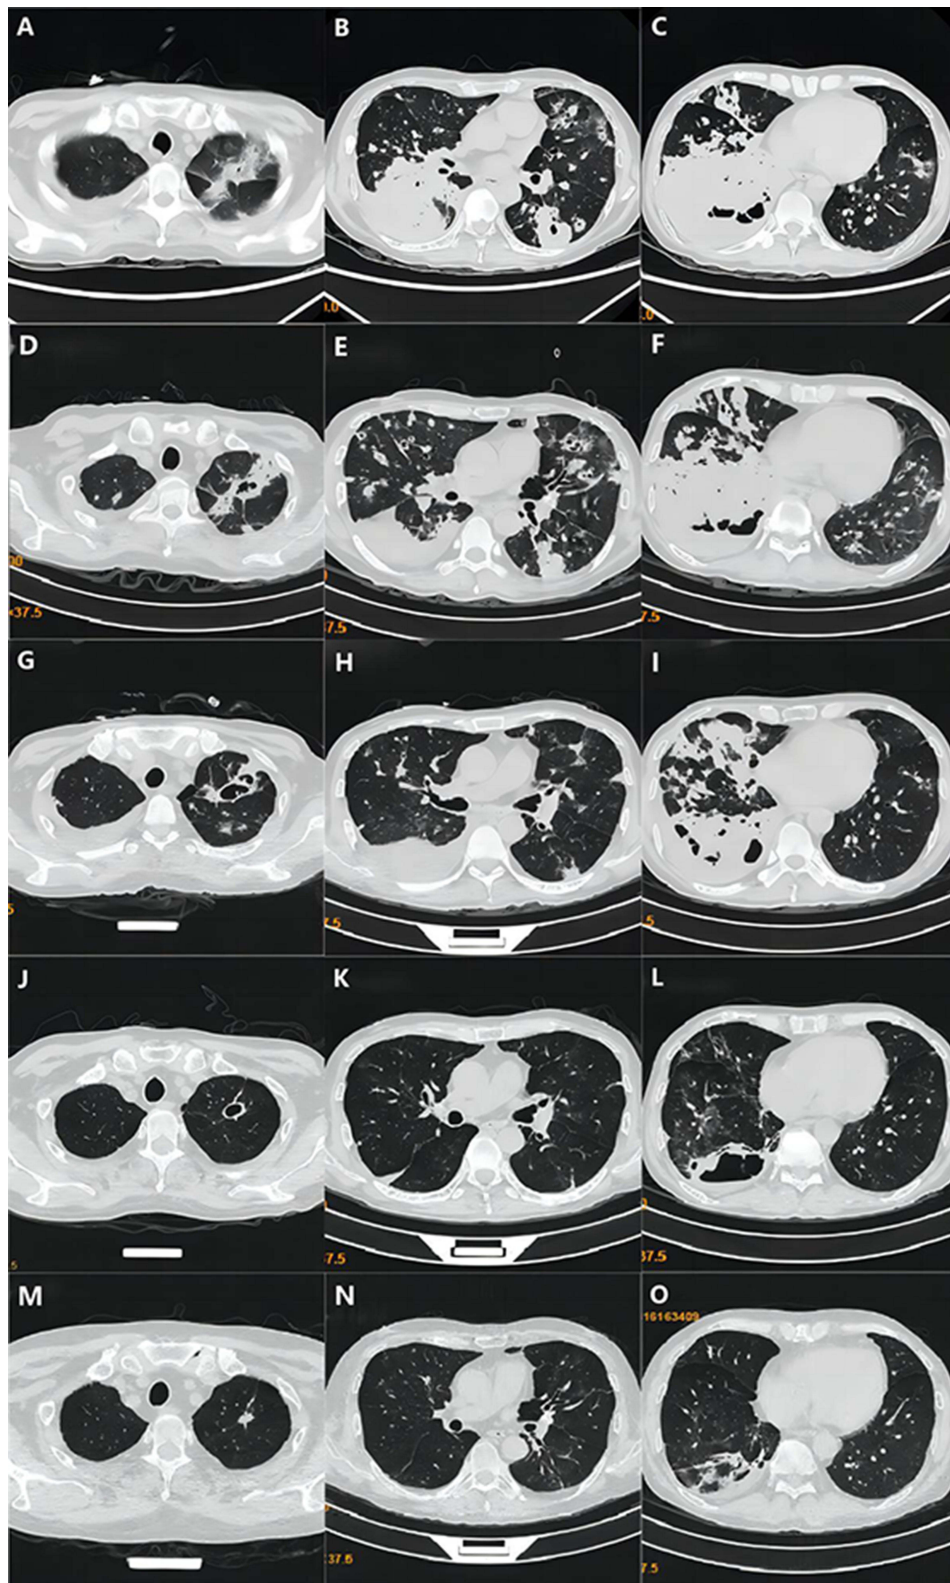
Chest CT imaging changes of the patient. (A–C) The imaging result on March 30 shows the both lung fields was showing mosaic changes, interstitial thickening, solid nodules, ground glass nodules. The right lung There were pleural effusion and flake-like high-density shadows with cavities inside. Striped shadow in the left upper lung. (D–F) The imaging result was on April 3. (G–I) The imaging result after 2 days after treatment (April 25). (J–L) The imaging result after treatment (June 7). (M–O) The imaging result after treatment (August 17) shows that the Lesion was further reduced.
